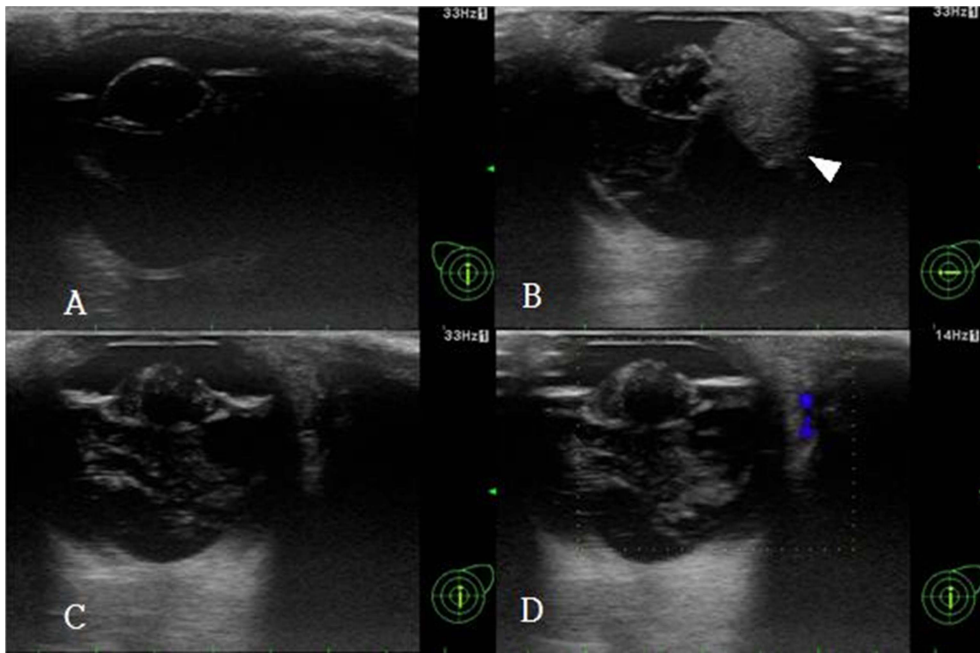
Ocular ultrasonography of the eye. (A) Vertical plane of the normal right eye, (B) horizontal plane, (C) vertical plane, and (D) Color Doppler examination of the left eye. A 1.3 cm × 0.8 cm, homogenously hyperechoic mass of ciliary body (arrowhead) was observed. Because of the mass, the lens was distorted medially. On Color Doppler examination, there was no blood flow distribution in the mass.
